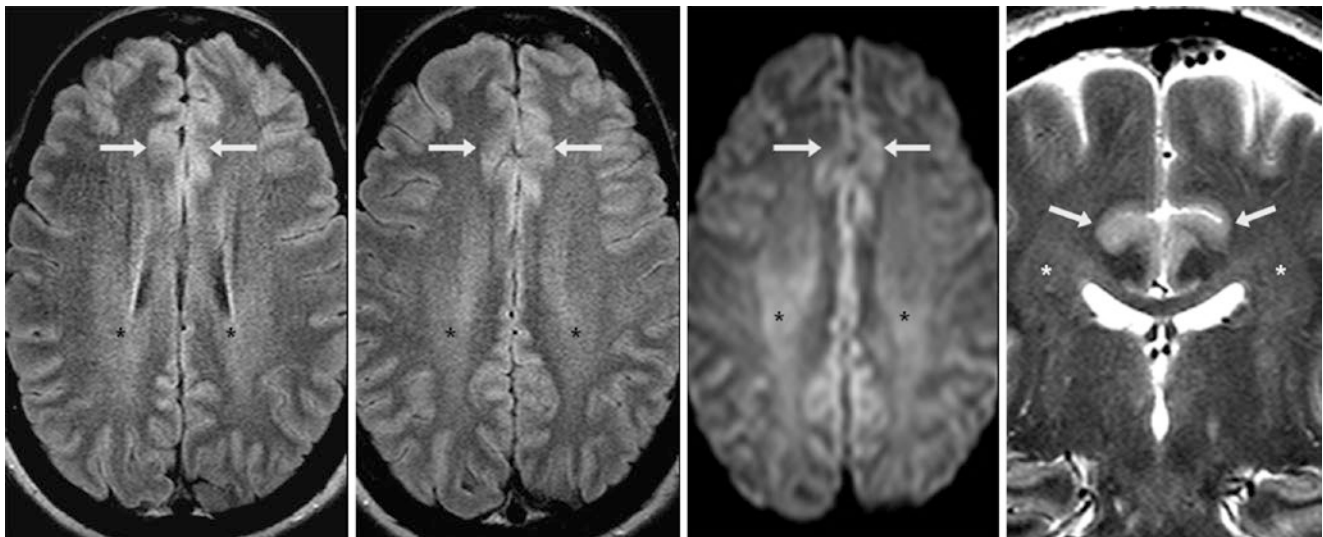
A 37-year-old had transient weakness that resolved hours later. A negative 3 T MRI with FLAIR (*left and left middle*), DWI (*right middle*), and coronal T2WI (*right*) showed normal, mild hyperintensity within the PVWM diffusely and bilaterally, centered within the centrum
